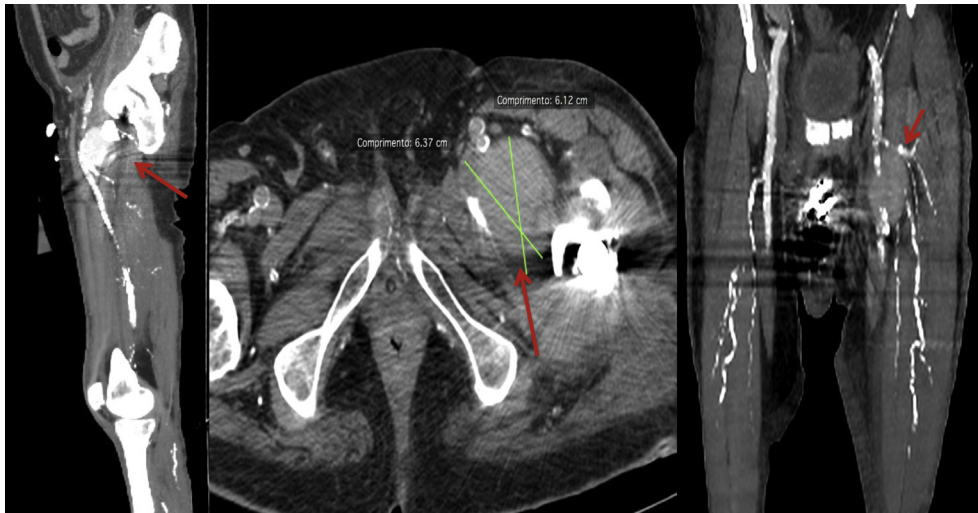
From left to right, the red arrows show contrast CTscan with PSA. CTA confirmed the presence of a 6.37 cm × 6.12 cm PSA in the DFA.
